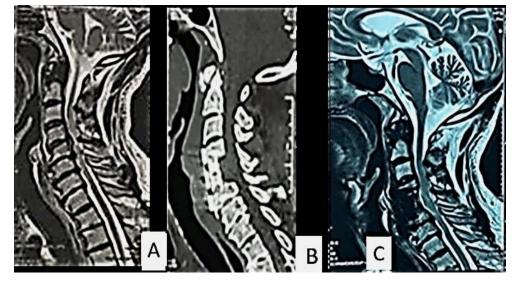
A case of C5 corpectomy. A; preoperative MRI T2WI sagittal views on the cervical spine show disc prolapse at C4-5 and C5-6 with canal stenosis and cord compression. B; postoperative CT scan sagittal views on the cervical spine showing a good alignment of the pyramesh cage. C; postoperative MRI T2WI sagittal views on the cervical spine showing adequate cord decompression.
